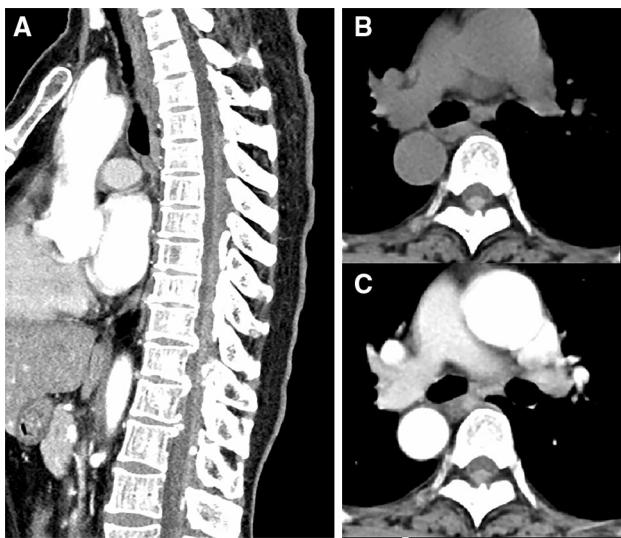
Computed tomographic scan images. Sagittal a image showed a striped lesion located posteriorly within the spinal canal from T3 to L1 levels, with higher density than spinal cord. Multiple OLF was also observed. Axial pre- (b) and post-iodinated agents (c) images of the thoracic spine showed a non-enhancement lesion between spinal cord and ossified ligamentum flavum
